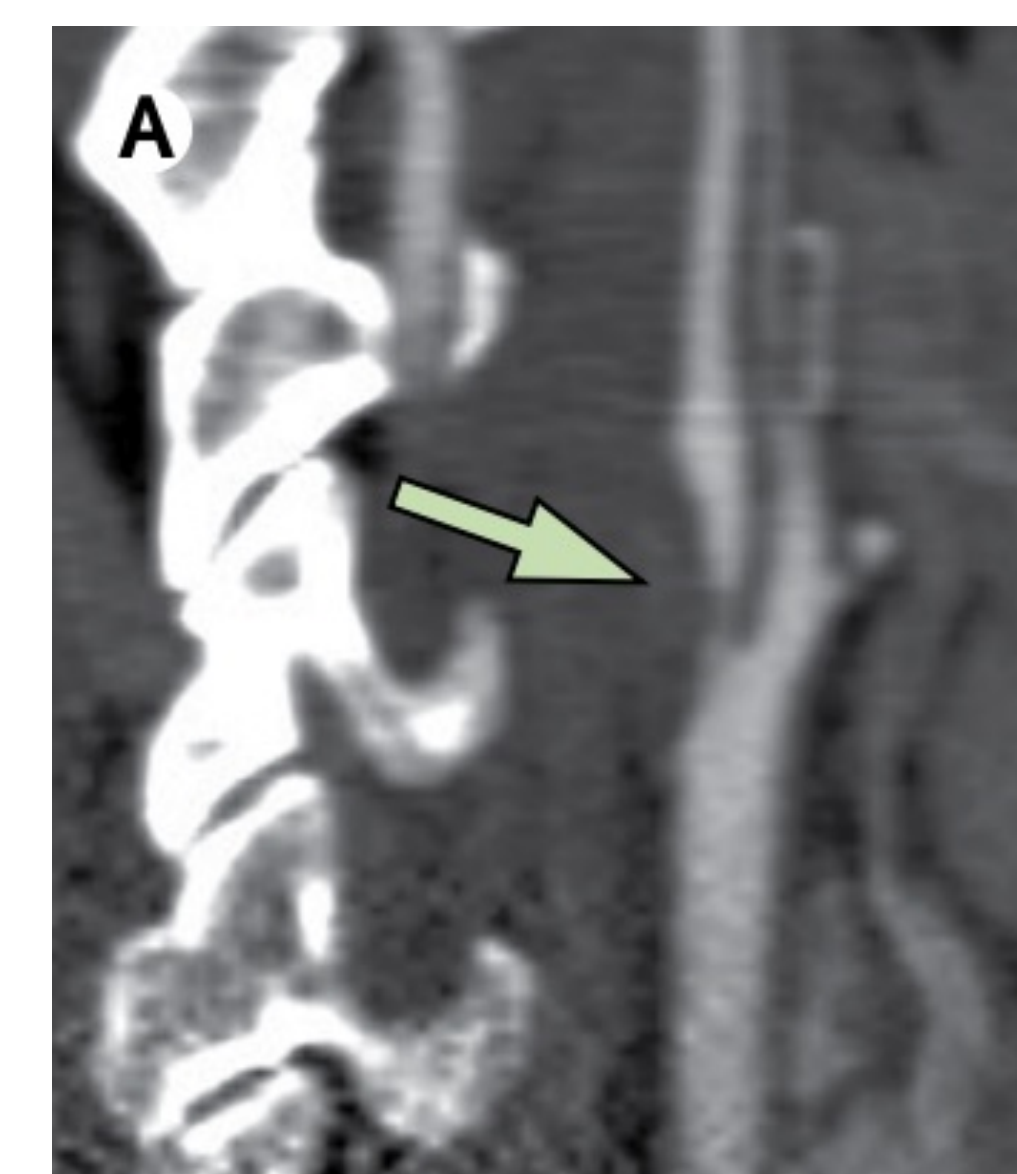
A blockage of the internal carotid artery seen on a CT angiography (Campbell & Khatri, 2020, p. 131).
